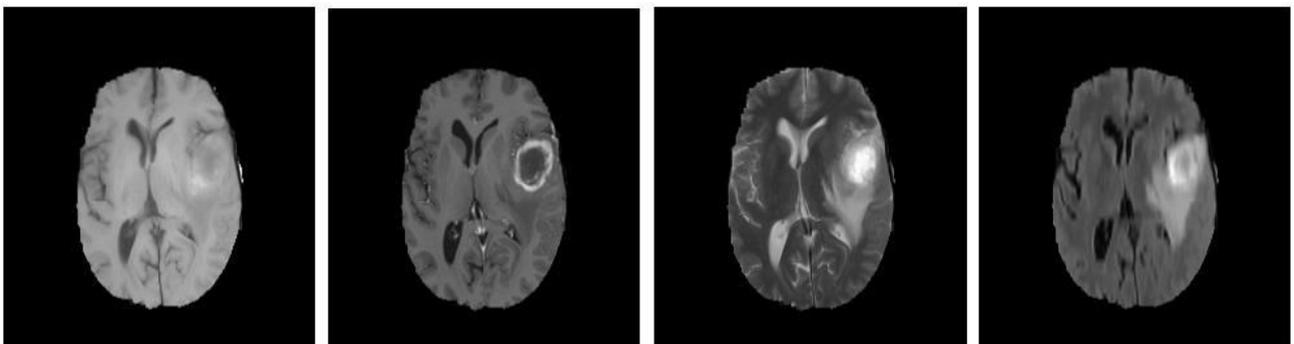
Four different MRI modalities showing a high grade glioma, each enhancing different subregions of the tumor. From left; T1, T1-Gd, T2, and FLAIR. Images are generated by using BRATS 2013 data<sup>5</sup>.
